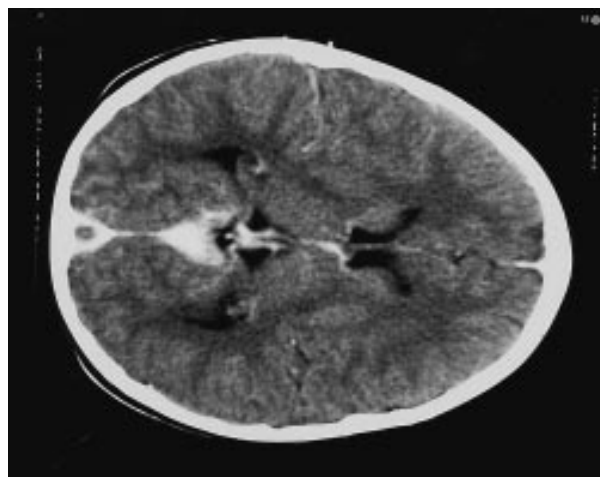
First CT scan of the patient, showing a thrombus within the superior sagittal sinus surrounded by contrast media—the so-called 'empty triangle sign'.
